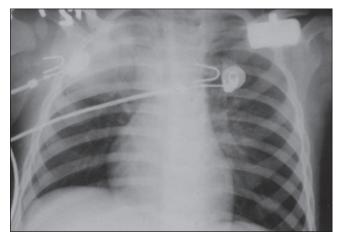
Post bronchoscopy X-ray showing bilateral expanded lung fields
